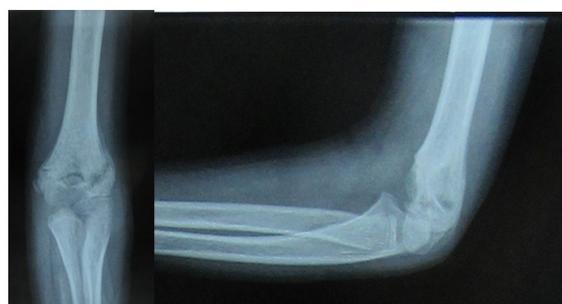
Follow-up X-rays (4th week) after pin removal
